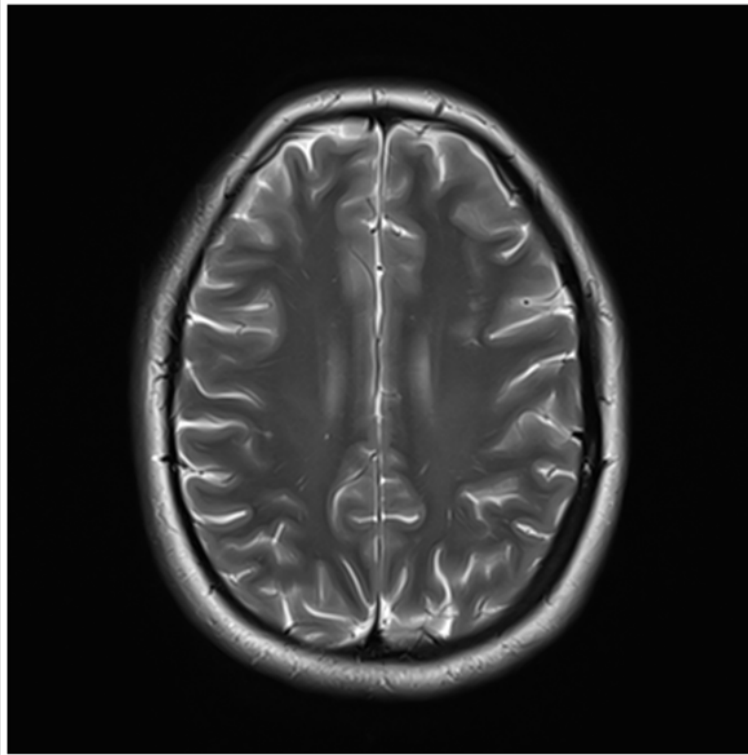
Follow-up MRI revealing a lesion with the central vein sign.
